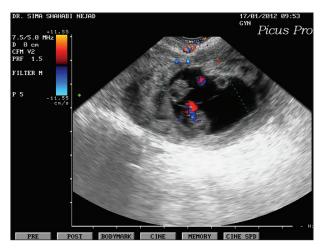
Ultrasound evaluation of the patient
